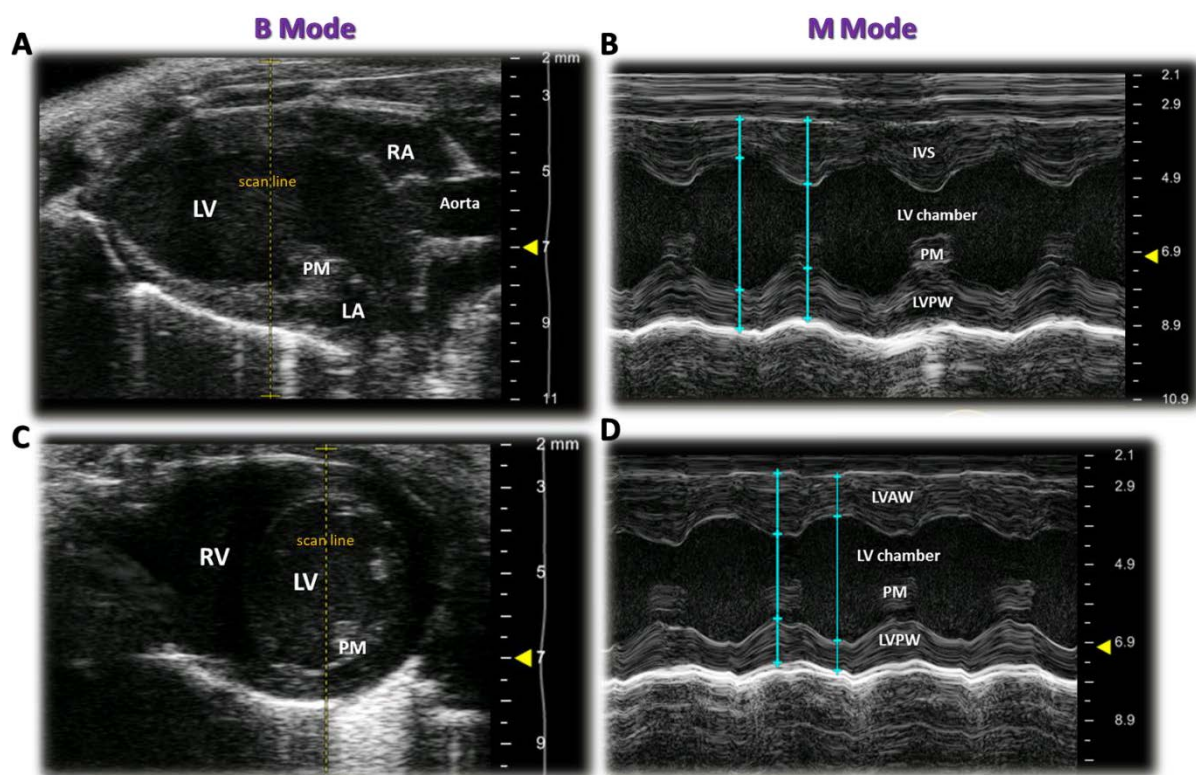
Echocardiography imaging in long and short axis view
